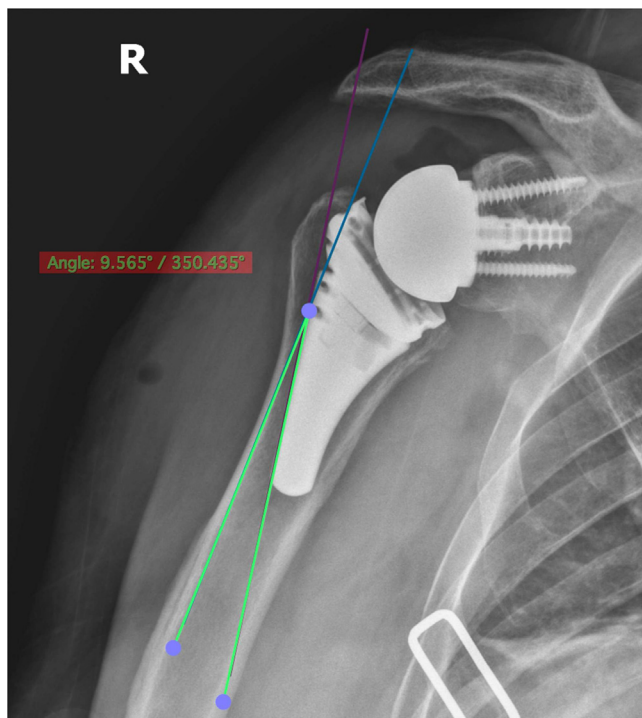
Initial postoperative radiograph demonstrating a stem that was placed into valgus alignment. Note the difference of more than 9° between the alignment of the prosthesis and humerus.
